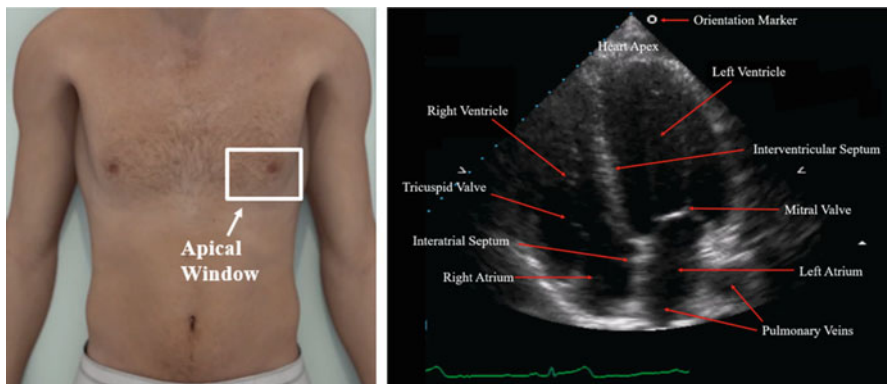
Left panel: ultrasound cardiac window for apical views. Right panel: apical four chamber view
